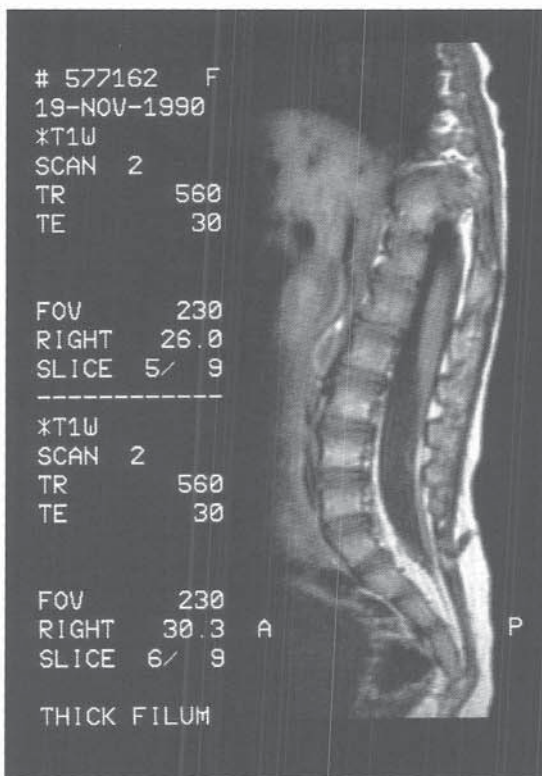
MRI of a patient with back pain and lower extremity weakness. The conus medullaris normally ends at L1 or L2 after 2 months of age. In this patient, the filum terminale is thickened, appearing to “tether” the conus medullaris distally.
